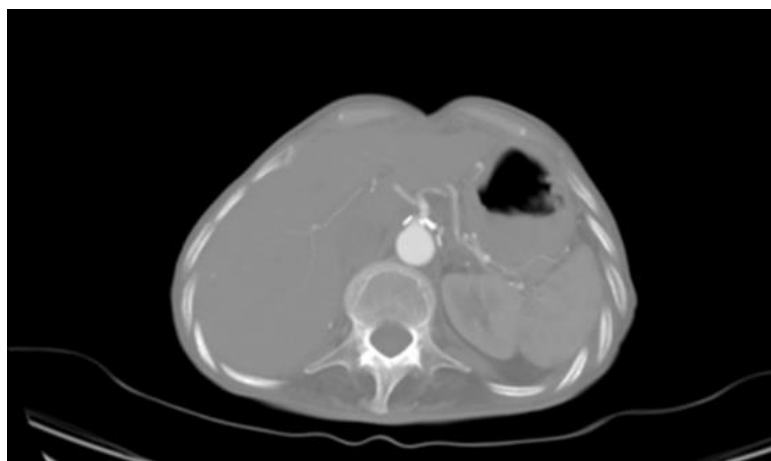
Follow-up CT angiography: patent celiac trunk without stenosis
